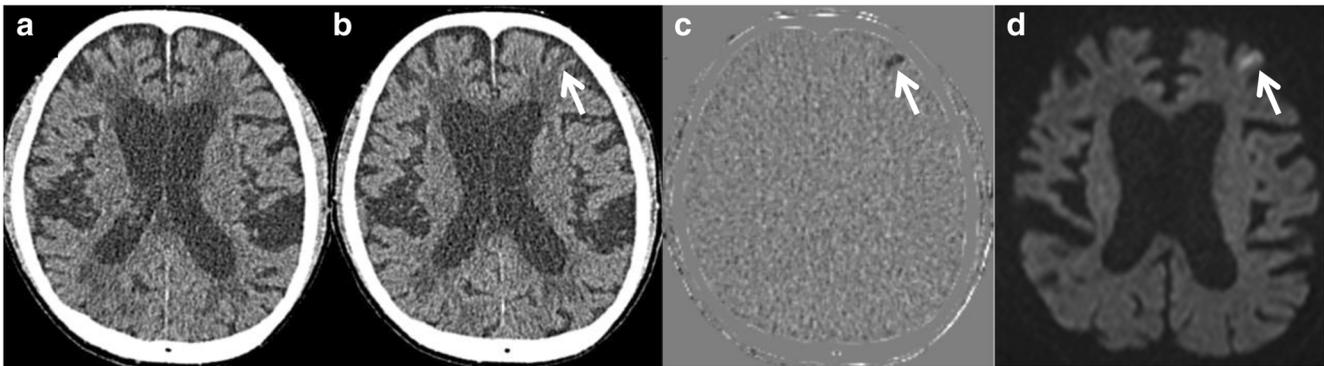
A case of an 82-year-old male with a fresh infarct in the left frontal lobe (arrow). From the left the (a) previous CT, (b) current CT, (c) TS CT and (d) DWI image ($B = 1000$) are shown. The lesion was correctly marked by none of the readers without TS and 93% (13/14) with TS
